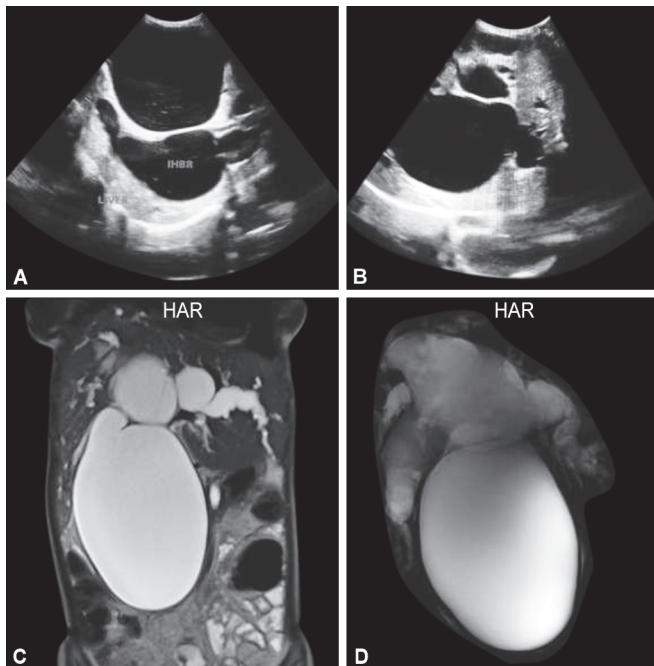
to D: Choledochal cyst (type IVB—Todani classification): (A and B) Ultrasound showing the saccular type of dilatation of the common bile duct with similar sacculation in relation to the left intrahepatic biliary duct; (C and D) Magnetic resonance cholangiopancreatography confirms saccular dilatations in relation to the main common bile duct and the left hepatic duct suggestive of intrahepatic and extrahepatic saccular type of choledochal cyst
